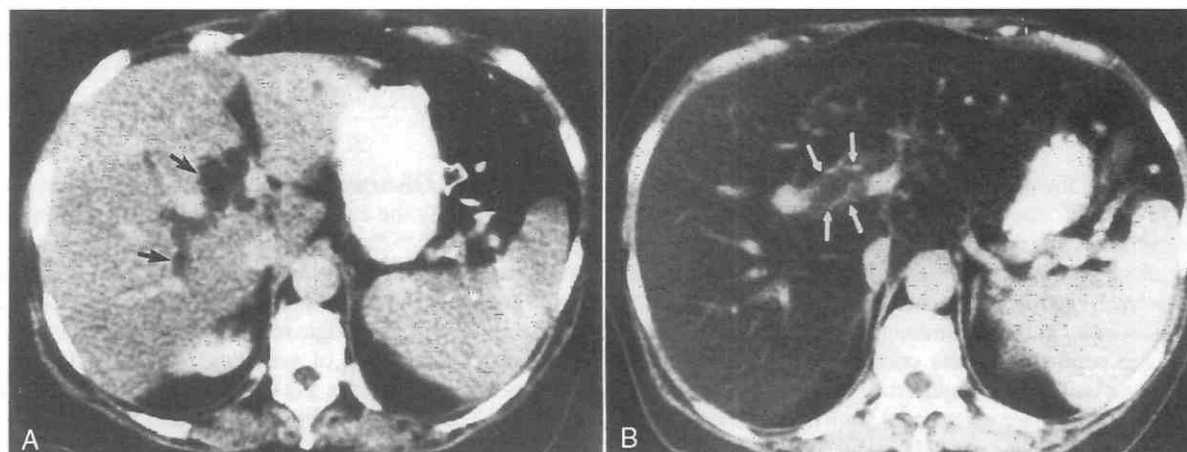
Biliary dilatation in a fatty liver. A, Postcontrast CT scan shows mild fatty infiltration of the liver with biliary dilatation (arrows). B, Five months after A, dilated bile ducts (arrows) are indistinguishable from the hypodense fatty liver on this postcontrast scan. (From Quint LE, Glazer GM: CT evaluation of the bile ducts in patients with fatty liver. *Radiology* 153:755, 1984.)
